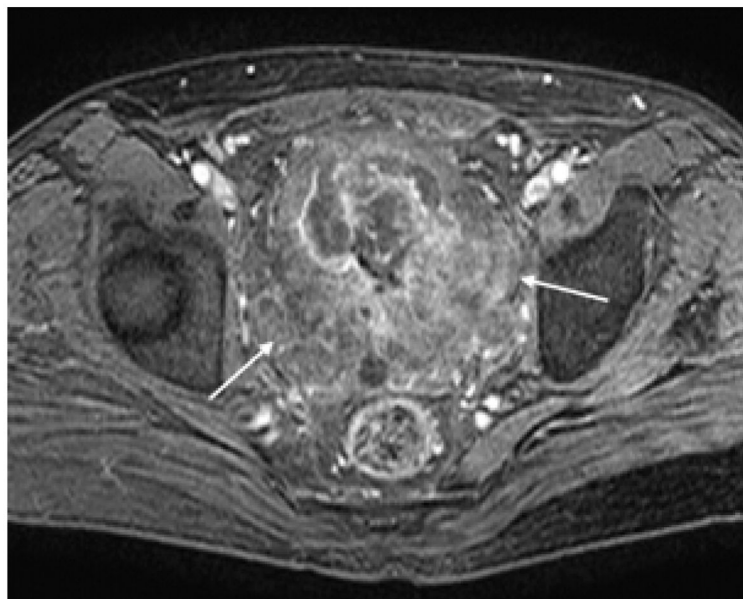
Contrast enhanced T1 weighted axial MRI image of the pelvis demonstrates an irregular enhancing mass filling the bladder. The margin of the mass is inseparable from the bladder wall. Irregular enhancement along the bladder wall (*arrow*) suggests transmural spread of disease.
